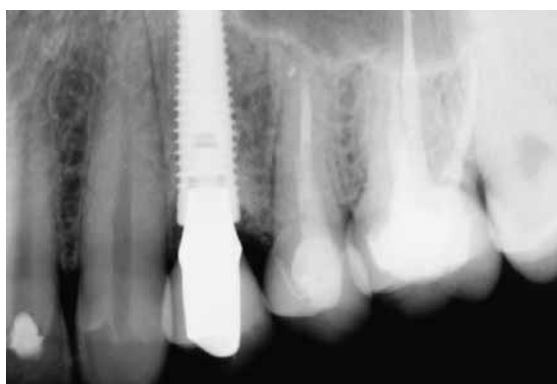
Periapical radiograph 3 years after implant placement.
